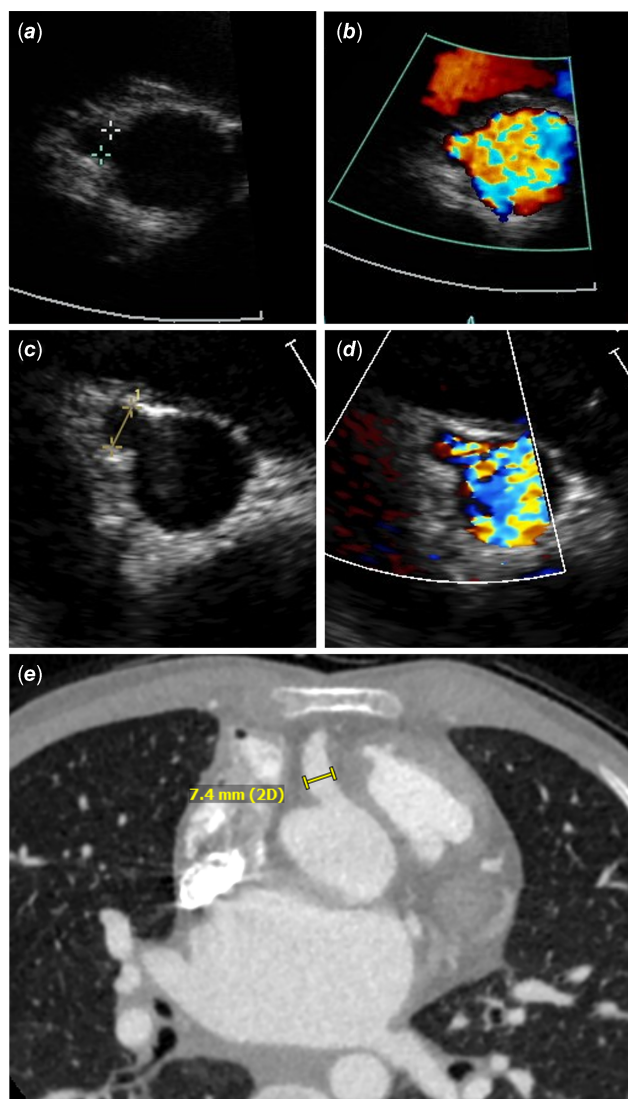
Coronary artery imaging by echocardiogram and CT for patient 7. Two dimensional and color Doppler echocardiogram of right coronary artery. a, b) 11 months (2.9 mm, Z = 4.41). c and d) 13 years (7.0 mm, Z = 9.83). e) 13 years (7.4 mm).
